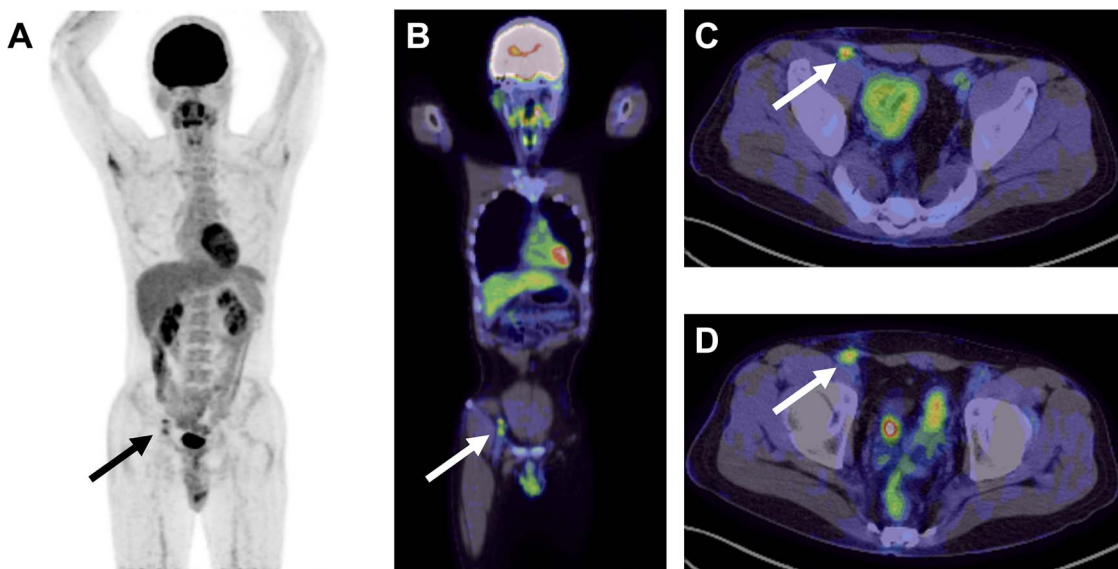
Post-chemotherapy 2-18fluoro-deoxy-D-glucose positron emission tomography (FDG-PET) images. (A) Maximum intensity projection (MIP) image, (B) MIP-fused image, and (C, D) fused PET-CT images. The arrows show two 10-mm right inguinal FDG-positive nodules.
